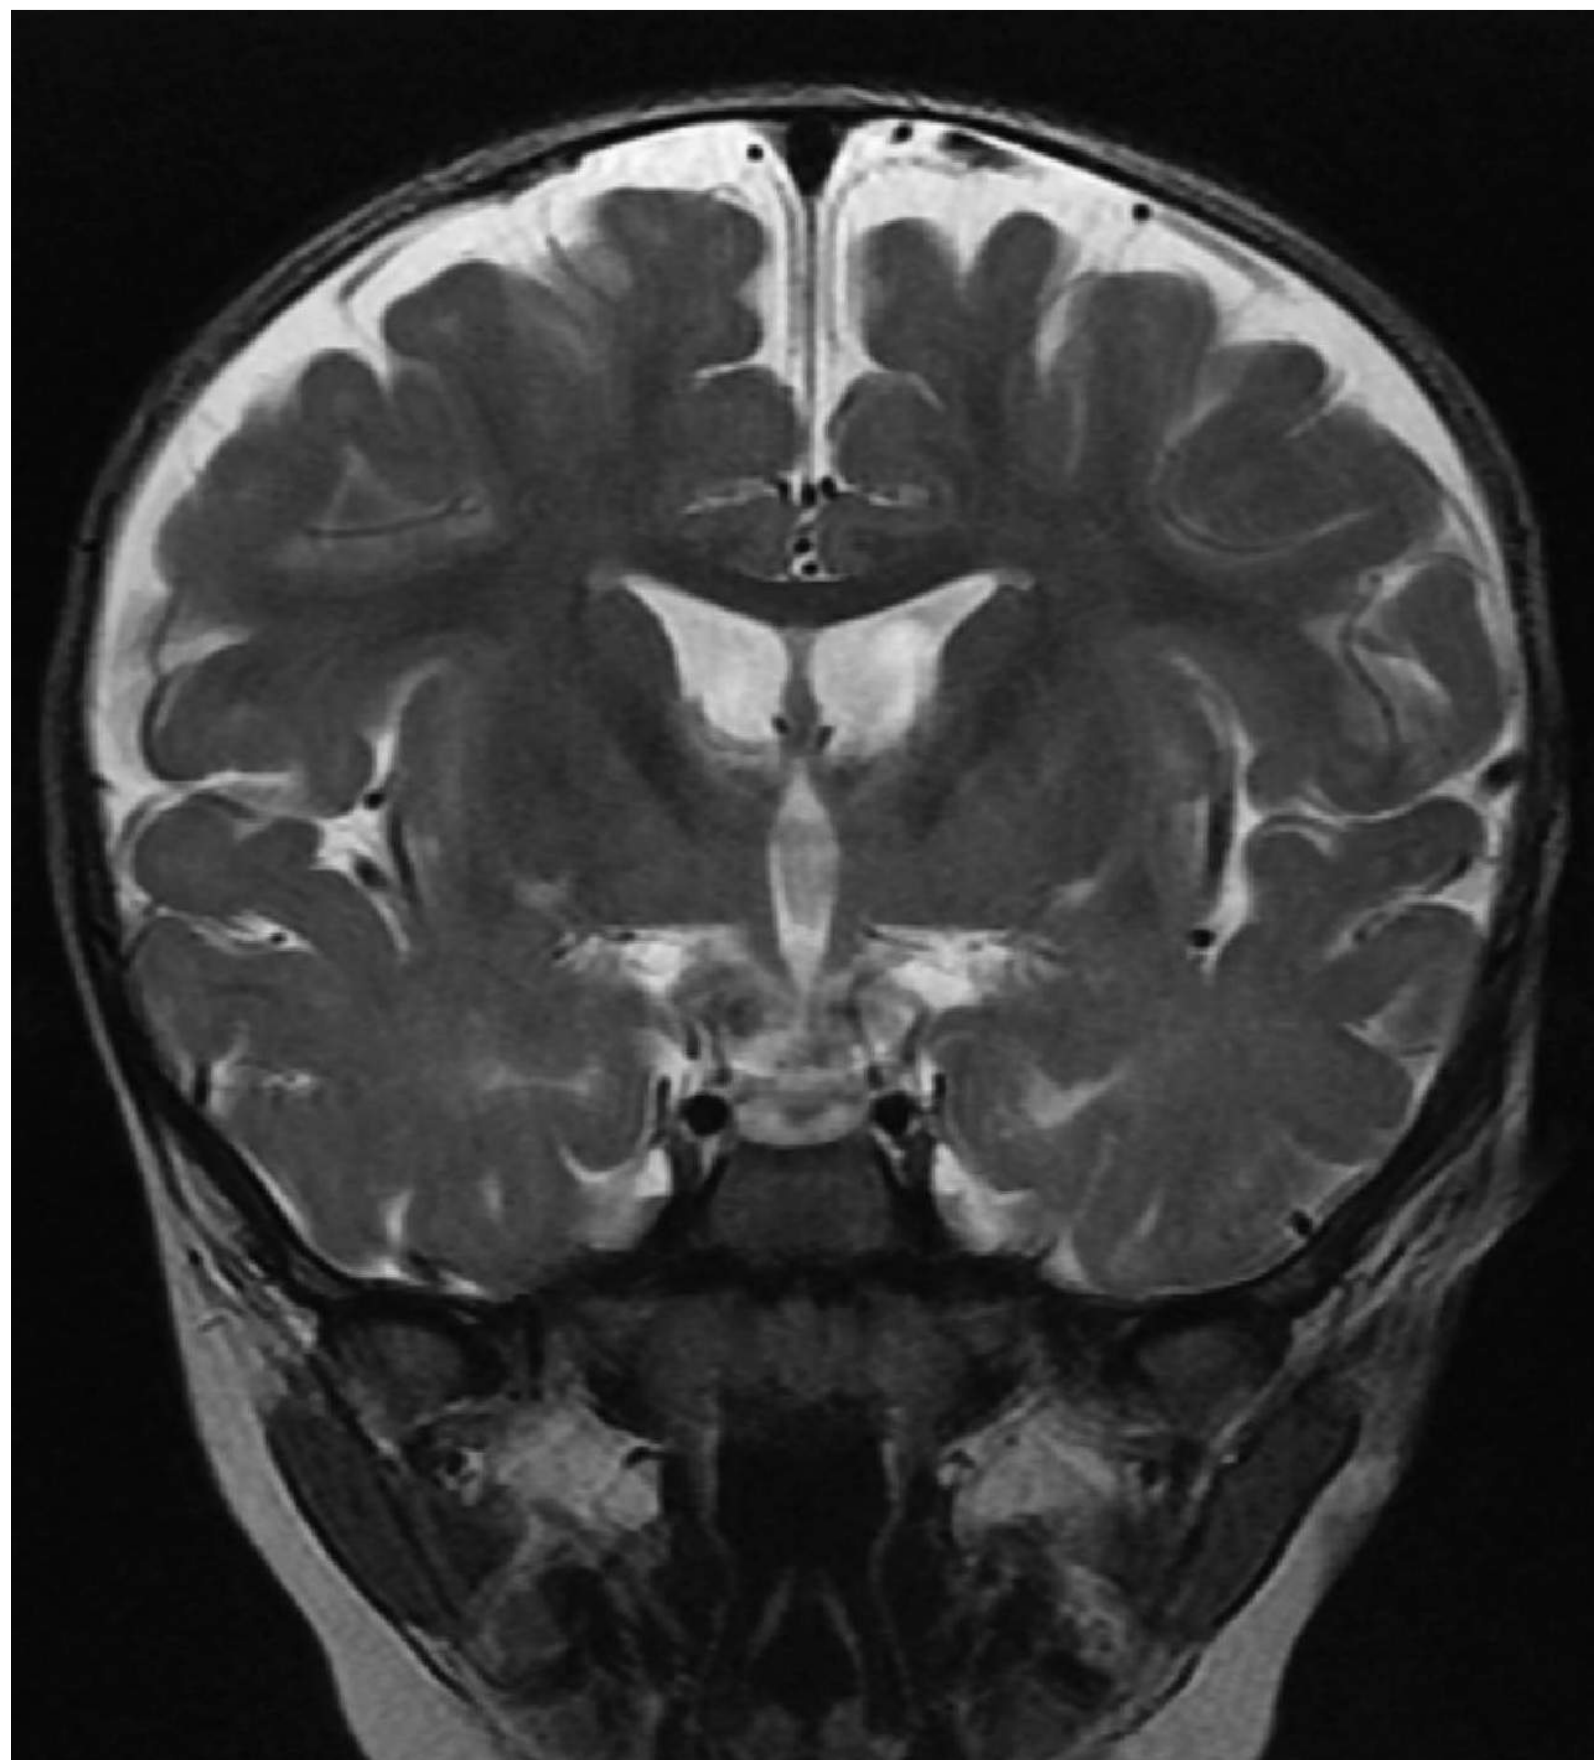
■ Benign Extra-Axial Fluid. This coronal T2-weighted MRI shows enlarged subarachnoid spaces (vessels running through). This can be a common finding in children with macrocrania. The enlarged spaces can be confused for subdural collections which will then raise the concern of abusive head injury. (Photo contributor: Marguerite Care, MD.)
